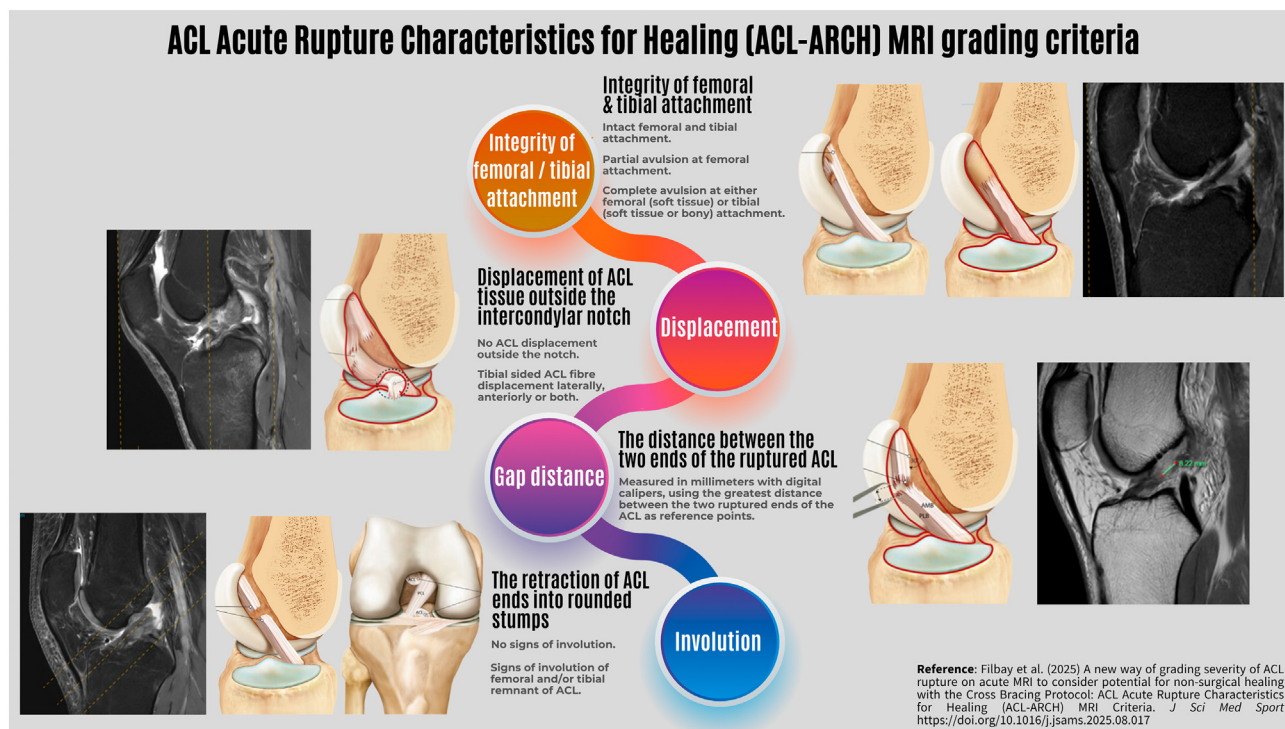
An overview of the ACL Acute Rupture Characteristics for Healing (ACL-ARCH) MRI criteria.
